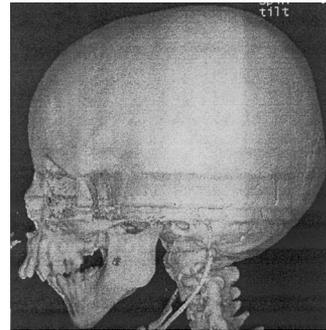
Three-dimensional CT scan demonstrating the normal, but diminutive, mandible.
